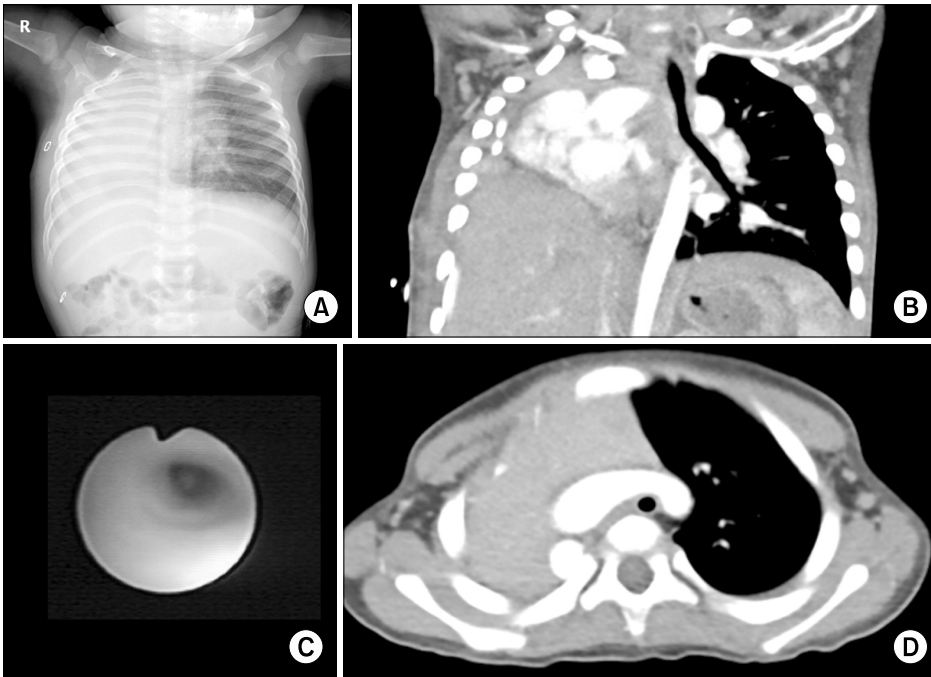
(A) Chest radiography before the operation. (B) Right lung agenesis (circle). Note that the left bronchial stump was missing. (C, D) Combined tracheal compression between the vertebral body and aortic arch was found on a computed tomography scan and by bronchoscopy (arrow).
